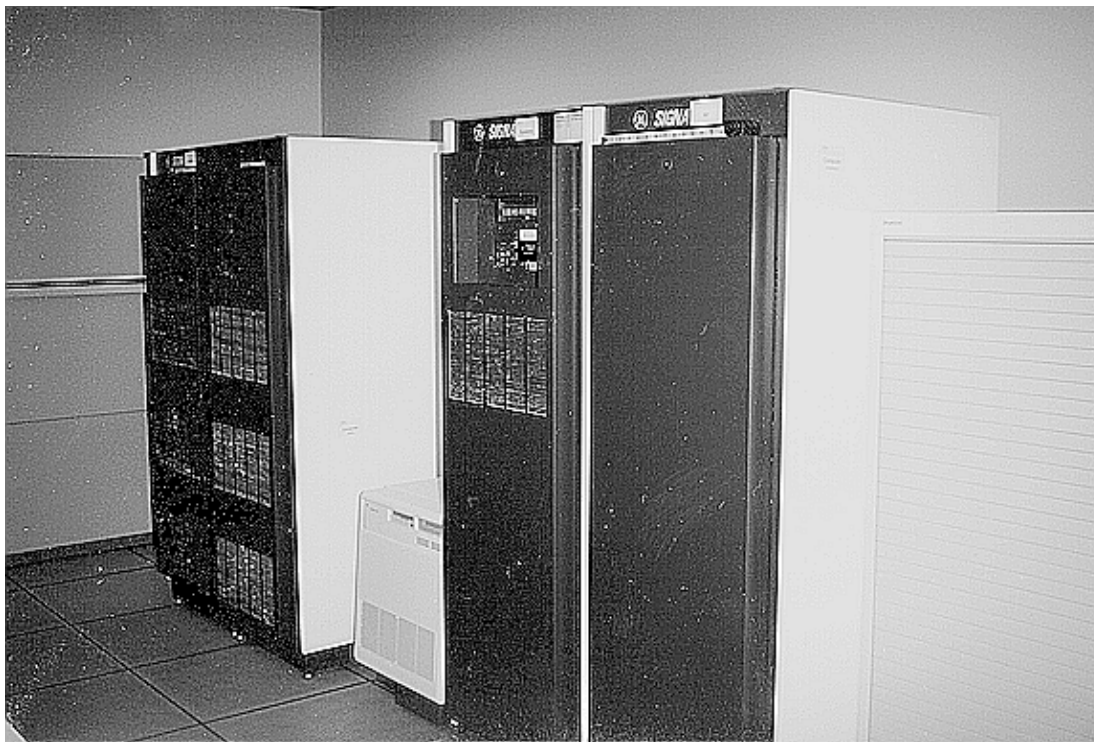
General Electric (GE) computers that control the MRI system.
